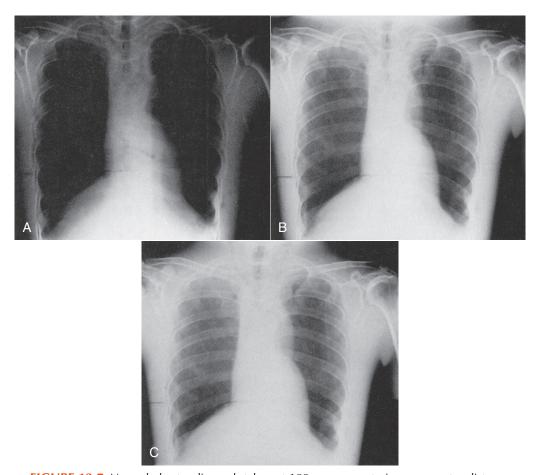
Normal chest radiograph taken at 100 cm source-to-image receptor distance (SID). B, If the exposure technique factors are not changed, a similar radiograph at 90 cm SID (A) will be overexposed, and at 180 cm SID (C), will be underexposed. (Courtesy Kurt Loveland, Southern Illinois University.)
